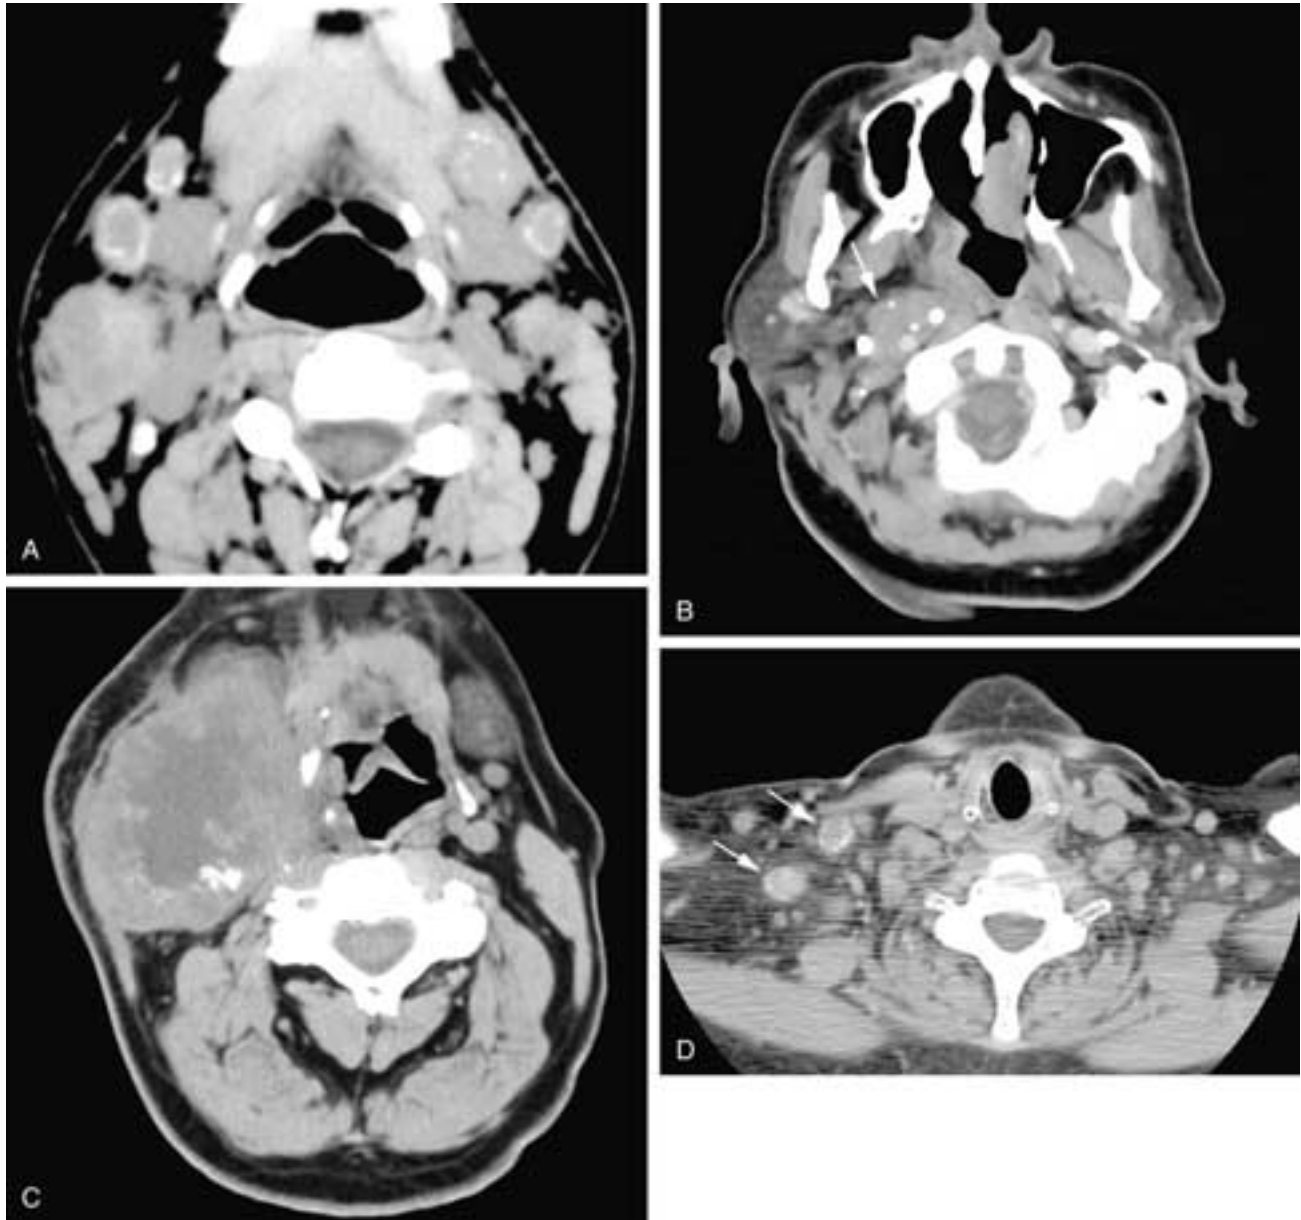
Axial contrast-enhanced CT scans. In A, there are multiple bilateral level I nodes with punctate calcifications around their peripheries. There is a small, dense calcification in the right level V area that was also a lymph node. This patient had amyloidosis. In B, there is a large right retropharyngeal lymph node (arrow) with calcifications both within it and at its periphery. This patient had squamous cell carcinoma. In C, there is a huge right level I node that is necrotic, with extracapsular tumor spread. In addition, there are calcifications within the periphery of the necrotic region. This patient had squamous cell carcinoma. In D, there are two right supraclavicular nodes with calcifications both within the nodal substance and at the nodal periphery (arrows). This patient had metastatic adenocarcinoma.
